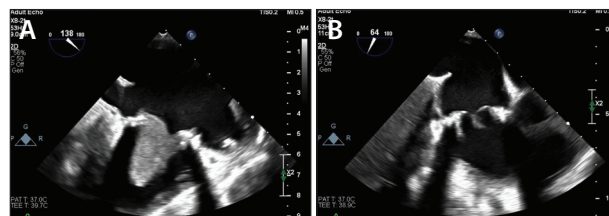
Echocardiogram showing bioprosthetic tricuspid valve with large adherent vegetation (A). Post-AngioVac TEE showing significant improvement in appearance of vegetation (B).
